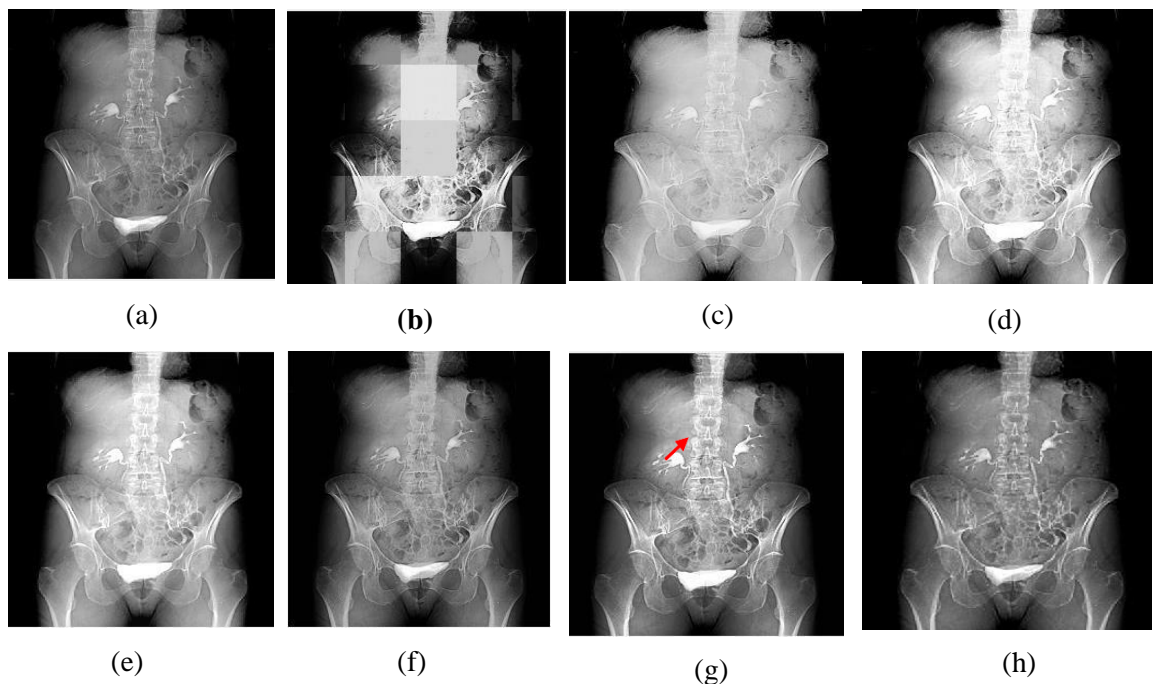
3.6 Input "CT-3" image and it's associated enhanced images (a) Input image, (b) S-curve, (c) AGC-DWT, (d)AGC-WHD, (e) GAGC-DWT, (f) EBCHE, (g) TCHE-DWT, (h) Proposed technique
